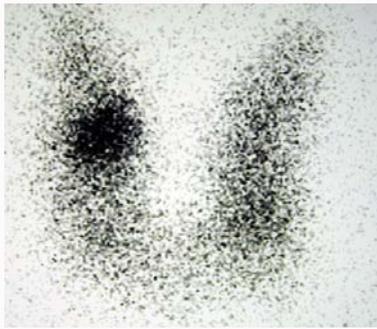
^{99m}Tc scintigraphy showing a hot nodule at the right thyroid region.
